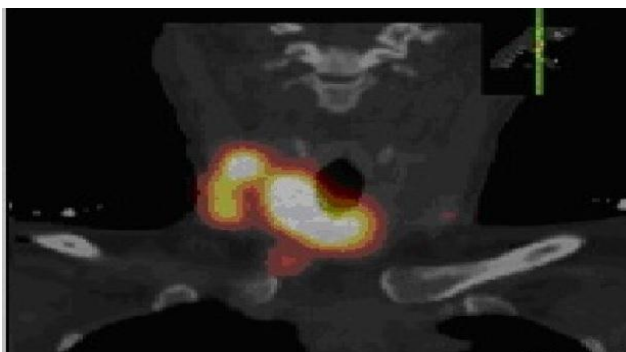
Lymphoscintigraphy acquired at 1 h after ⁹⁹Tc-DX injections. The SPECT image with invasive PTC located in the right lobe shows three SLNs. Three SLNs are seen in the right lateral compartment (level III and IV)
